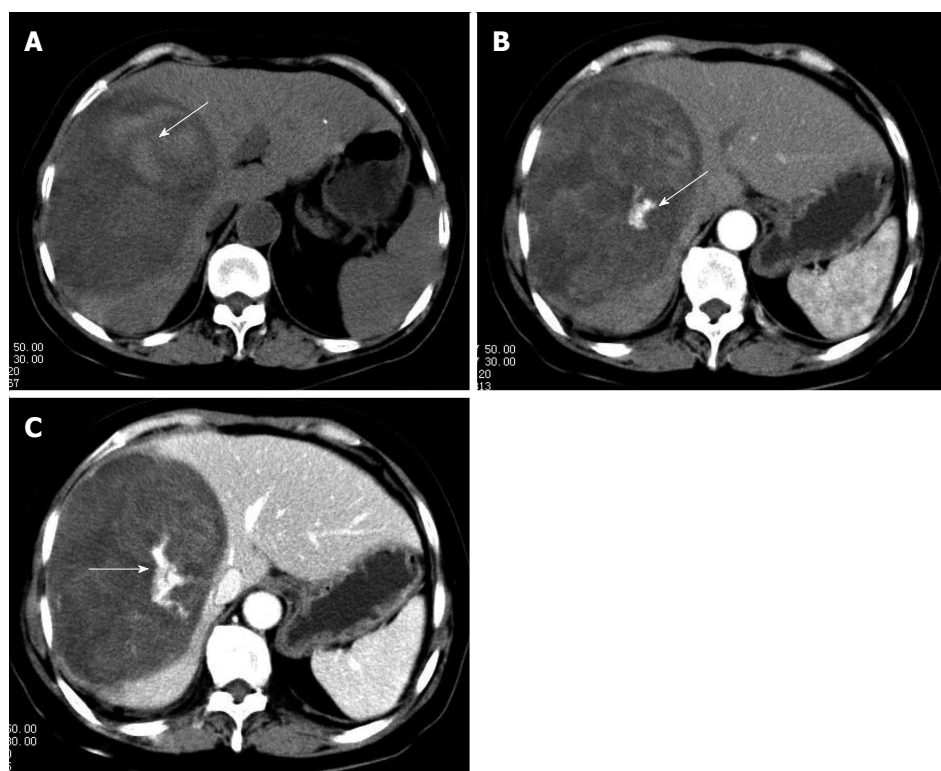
Computed tomography scan. A: Plain computed tomography scan reveals an oval shaped heterogeneous hypoattenuating mass with hyperattenuating foci (arrow) which suggests hemorrhage; B: Dominant mass lesion shows heterogenous enhancement with hyperattenuating enhanced foci (arrow), which indicate vasculature, in arterial phase; C: Dominant mass shows progressive enhancement and hyperattenuating enhanced foci enlarged in portal phase (arrows).
